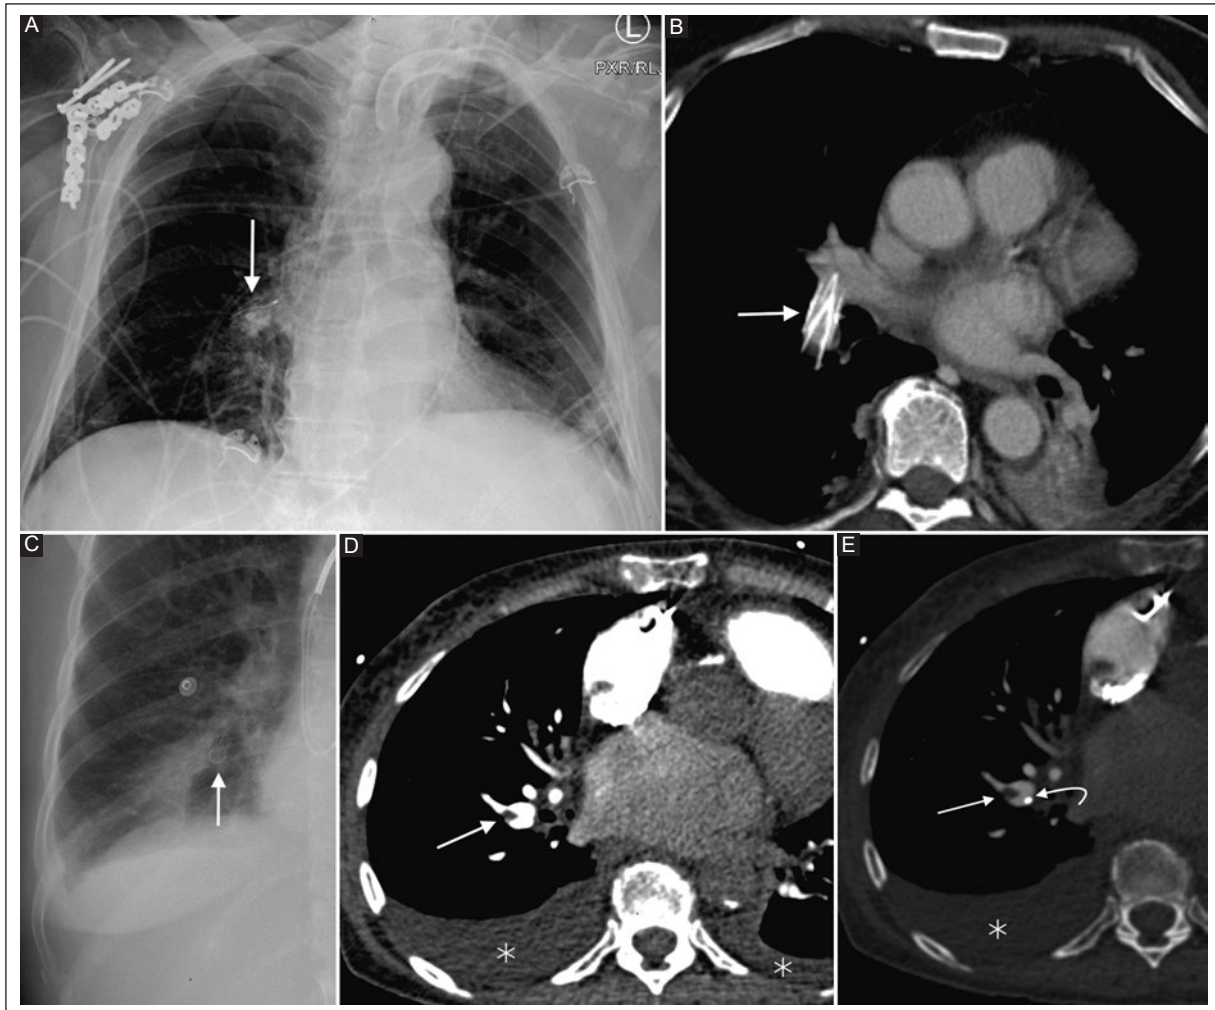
Female patient with a history of multiple episodes of pulmonary embolism. A: chest radiograph, anteroposterior view. A radiopaque object is observed, with a mesh appearance, occupying the interlobar artery corresponding to a medical device embolized to the pulmonary circulation (inferior vena cava filter) (arrow). B: CTPA, axial image. An inferior vena cava filter is identified in the interlobar artery (arrow). C: patient with chest pain, chest X-ray, posteroanterior view focused on the right lower lobe. A radiopaque loop-shaped foreign object is seen projected in the right lower lobe (arrow); D-E: CTPA, axial image. Opacification defect partially occupying the right lower lobe artery in relation to pulmonary embolism (arrow). By modifying the window, a radiopaque image is identified inside the pulmonary artery lumen for the left lower lobe in relation to the catheter fragment (curved arrow). Bilateral pleural effusions (asterisks).
